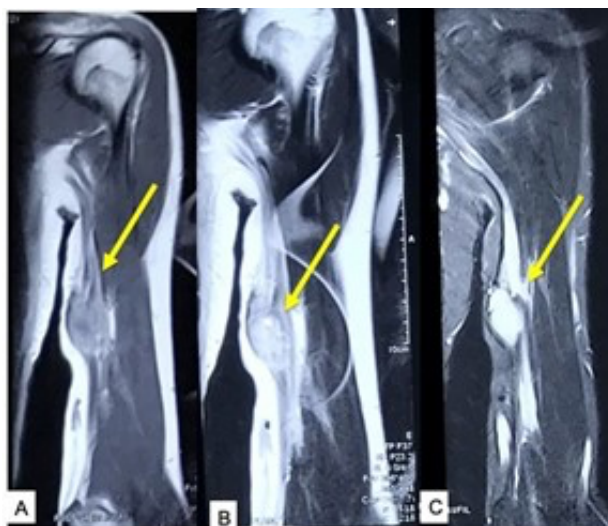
(A–C) MRI images of arm showing median nerve schwannoma (arrow-marked). Source: Figure by authors.
